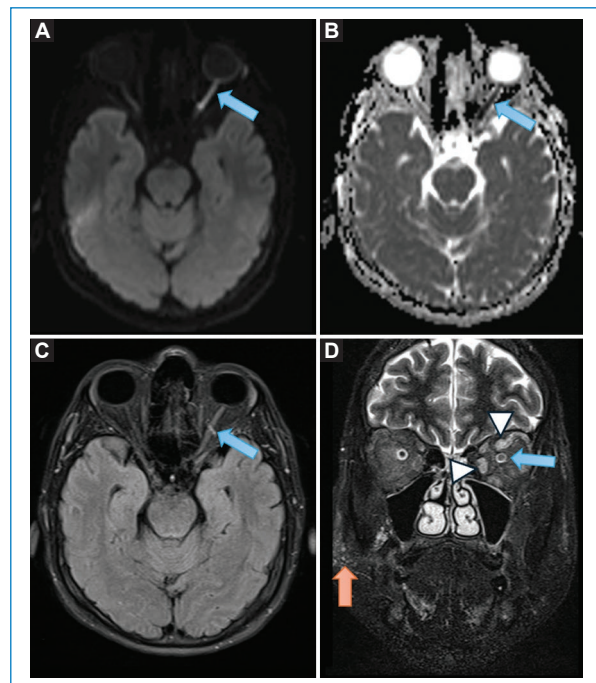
Lesion throughout the intraorbital segment of the left optic nerve, with restriction on DWI diffusion-weighted sequences (A) and ADC mapping (B), and hyperintense on axial FLAIR (C) and coronal STIR (D) sequences compared to the contralateral optic nerve, consistent with an acute infarction of the left optic nerve (blue arrow), associated with hyperintensity of the intraorbital muscles related to edema (arrowhead). Punctate hyperintensities are observed in the right zygomatic subcutaneous tissue related to changes following platelet-rich plasma infiltration (orange arrow).
